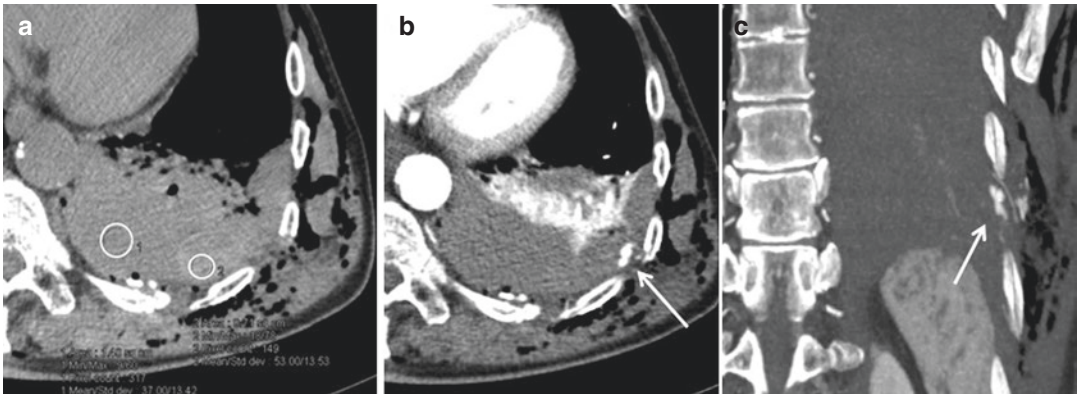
Hemothorax. Axial CT-scan at baseline (a) shows a posterior pleural fluid collection. As blood may not be the only fluid encountered in the injured pleural space, measurement of the attenuation of pleural space fluid collection should be performed. In (a), the pleural fluid is homogeneous with a marginal hyperdense area:
